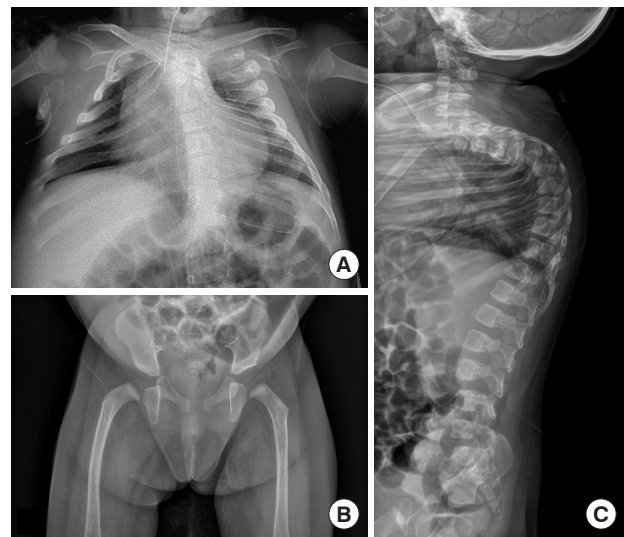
Radiographs of a 7-month-old girl with campomelic dysplasia showing (A) a bell-shaped thoracic cage, 11 pairs of ribs, scapular hypoplasia, (B) vertical ischia, bowing of the right proximal femur, and (C) thoracic kyphosis.
